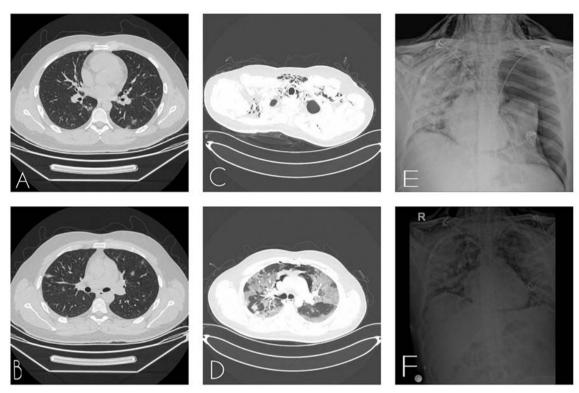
A-B: In the middle and lower zones of both lungs, multi-focal nodular-shaped infiltrations with ground-glass opacity were observed, and the appearance was consistent with viral pneumonia. C-D: Diffuse emphysema appearance extending to the paravertebral area and the spinal adjacency of the medulla in the cervical level soft tissues, also continuing on the thoracic wall at the inferior along the parasternal area, also in the pericardial area and mediastinum, was observed. An infiltrative appearance was observed in both lungs, which was evaluated in favor of specific viral pneumonia forming a diffuse crazy-paving pattern appearance covering almost the entire parenchyma. A loculated pleural effusion with a depth of 6 mm was observed in the middle part medial of the right hemithorax. E: Total pneumothorax on left in lung x-ray. F: Expansion of the left lung after tube thoracostomi intervention.
